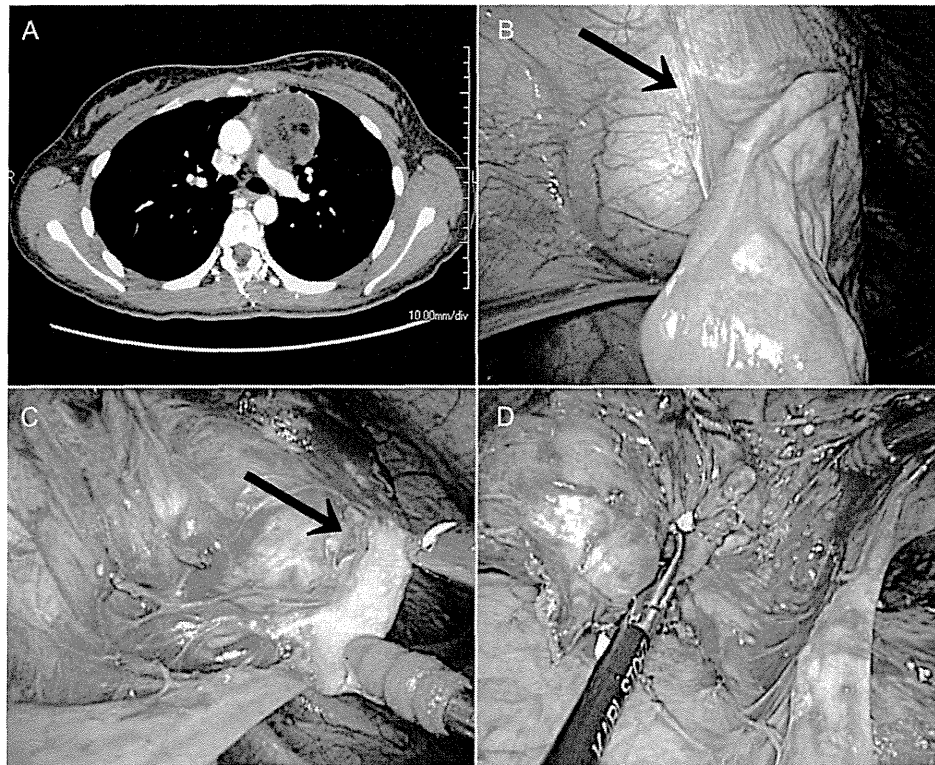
(A) Chest computed tomography image showing a well-circumscribed cystic tumour in the anterior mediastinum. (B) Thoracoscopic view showing adhesion between tumour and lung (arrow). (C) When dissecting the tumour from the phrenic nerve, the contents spilled due to breakage of the tumour capsule (arrow). (D) Aspiration of cystic components can provide a wider thoracoscopic view, leading to easier grasping and retraction from the tumour wall.
